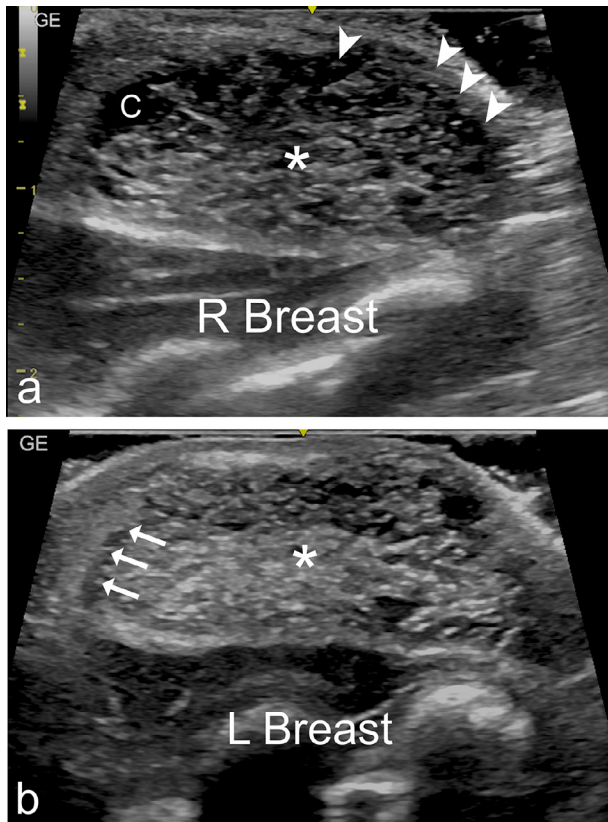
Ultrasound of right (A) and left (B) breast mass shows a well-defined (arrows), rounded, heterogeneously hypoechoic retroareolar mass (asterisks) with tiny peripheral cysts (arrowheads), the bigger of 2.5 mm in the right breast (letter C) and hyperechogenicity of surrounding subcutaneous soft-tissue
